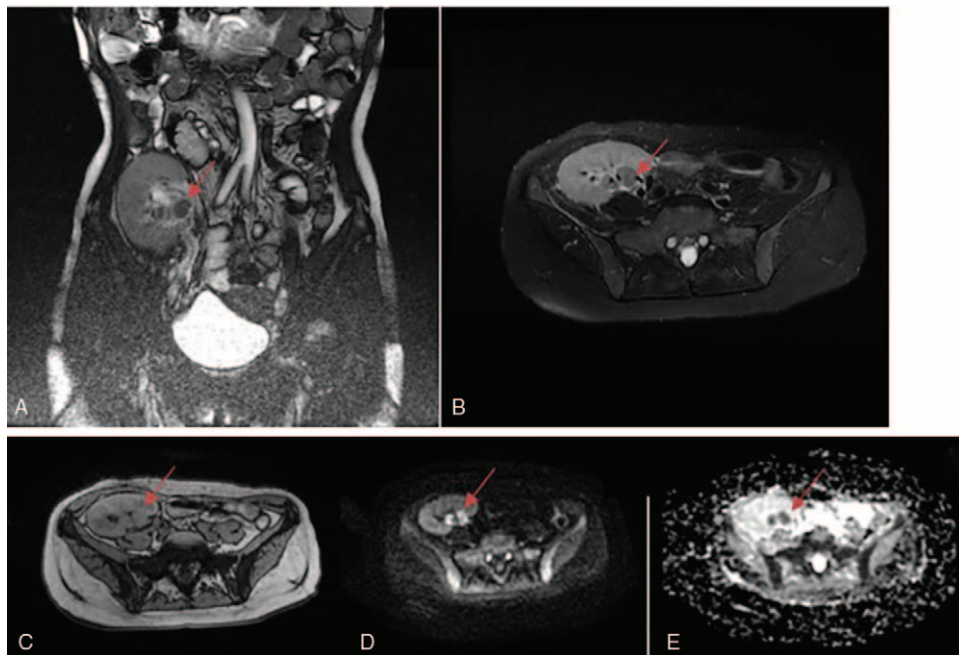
Magnetic resonance imaging depicted 2 abnormal emerging tumor-like masses in the transplant's renal medulla. The coronal (A)/axial (B) position of a T2-weighted imaging sequence revealed emerging masses with slight hypointensity. The axial position of a T1-weighted imaging sequence (C) also depicted emerging masses with slight hypointensity. The diffusion-weighted imaging sequence (D) depicted obvious hyperintensity with decreased apparent diffusion coefficient values (E). ADC=apparent diffusion coefficient, DWI=diffusion-weighted imaging, MRI=magnetic resonance imaging, T1WI=T1-weighted imaging, T2WI=T2-weighted imaging.
